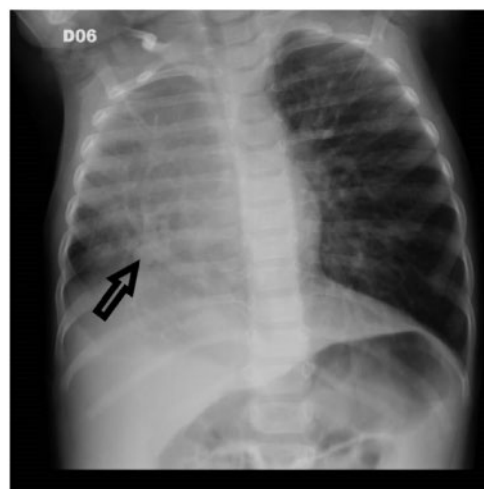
Chest X-ray showing the scimitar sign (arrow), hypoplastic right lung, and dextrocardia.
